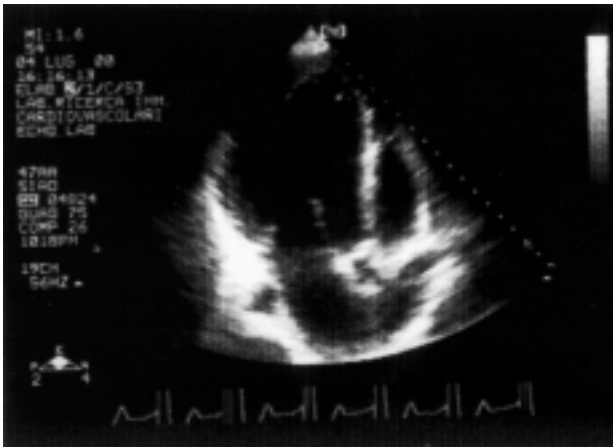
Transthoracic echocardiography showing calcification of the cusps of the aortic valve.
